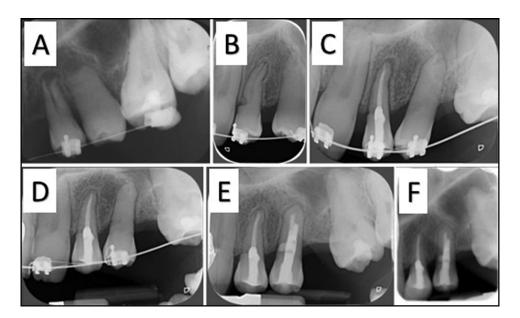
Radiographic presentation of the sequel of the 2 donors' healing, complications, endodontic treatment, and stability during and after orthodontic movement: A, maxillary right first premolar tied to the 0.012-in nickel-titanium archwire (10 months after transplantation); B, cervical external root resorption on the mesial root surface of the maxillary right first premolar (31 months after transplantation); C, endodontic treatment completed, with no signs of resorption of the mandibular right second premolar (36 months after transplantation); D, cervical external root resorption on the mesial root surface of the mandibular right second premolar (55 months after transplantation); E, endodontic treatment of the mandibular right second premolar completed; F, no relapse of the maxillary right first premolar and mandibular right second premolar root resorption (November 2015).
